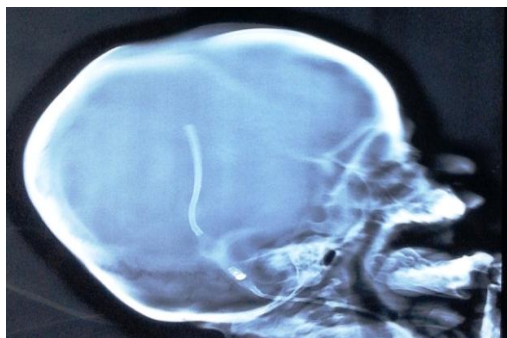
x-ray film used to assess the pressure of the valve
